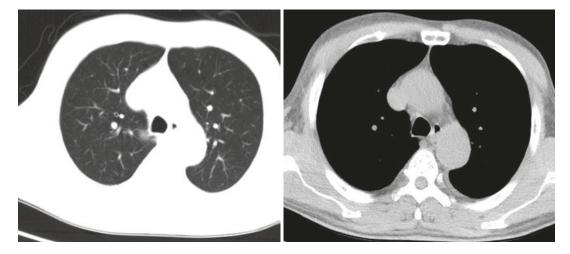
"C"-shaped trachea on CT images
